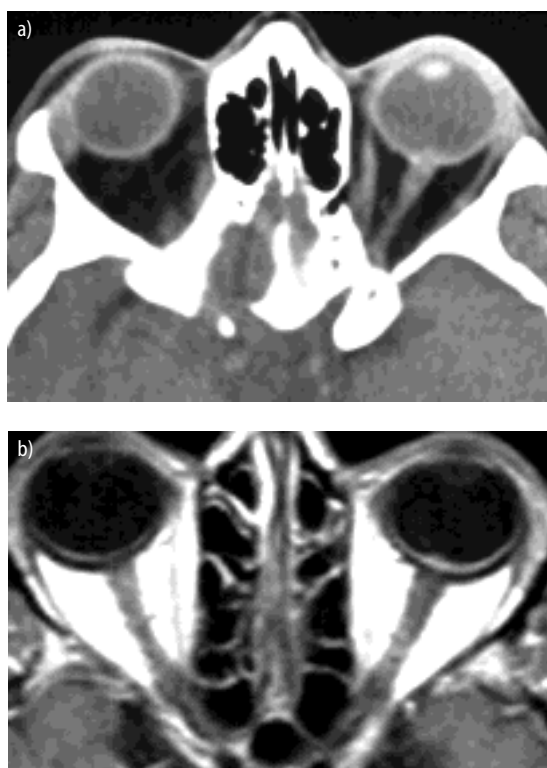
(a) CT-scan through the left bulbus (slice thickness = 3mm). There is a slight hyperdense lesion in the left eye at the macula. Otherwise, the CT is normal. (b) This T1-weighted (slice thickness = 3mm) image of the same patient after contrast injection shows a very faint enhancement in the optic nerve entry zone.
